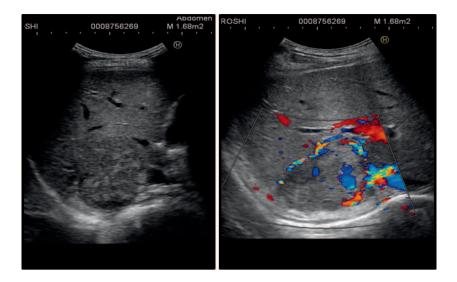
Abdominal ultrasonography shows a right adrenal tumor about 80 mm in diameter infiltrating to the liver. Tumor appears close to the IVC.
